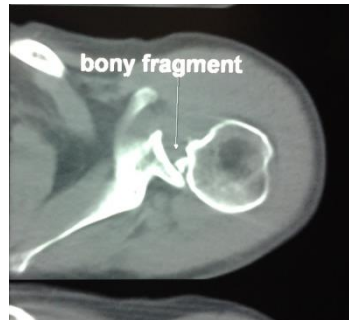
The cross sectional imaging of the shoulder showing the gross internal rotation of the head with a bone fragment in the joint (MRI of the shoulder). There was a very small defect of the anterior aspect of the humeral head less than 25 percent.
